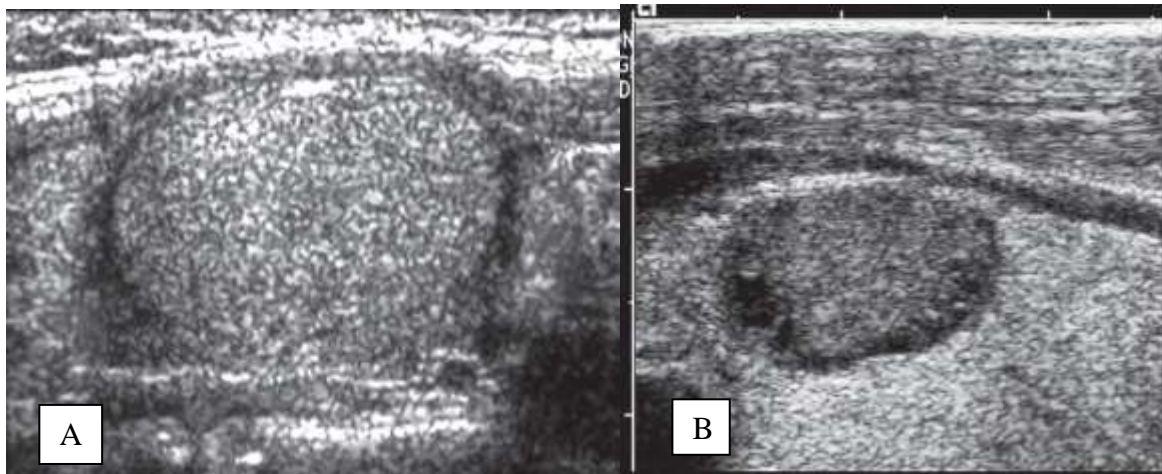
Atypical papillary thyroid carcinoma . Longitudinal images show two examples of the follicular variant of papillary thyroid carcinoma. A, oval isoechoic and B, hypoechoic mass that looks similar to the typical ultrasound appearance of a follicular neoplasm. This follicular variant is uncommon, accounting for 10% of cases of papillary carcinoma. The clinical course and treatment are the same as that of typical papillary thyroid carcinoma.
